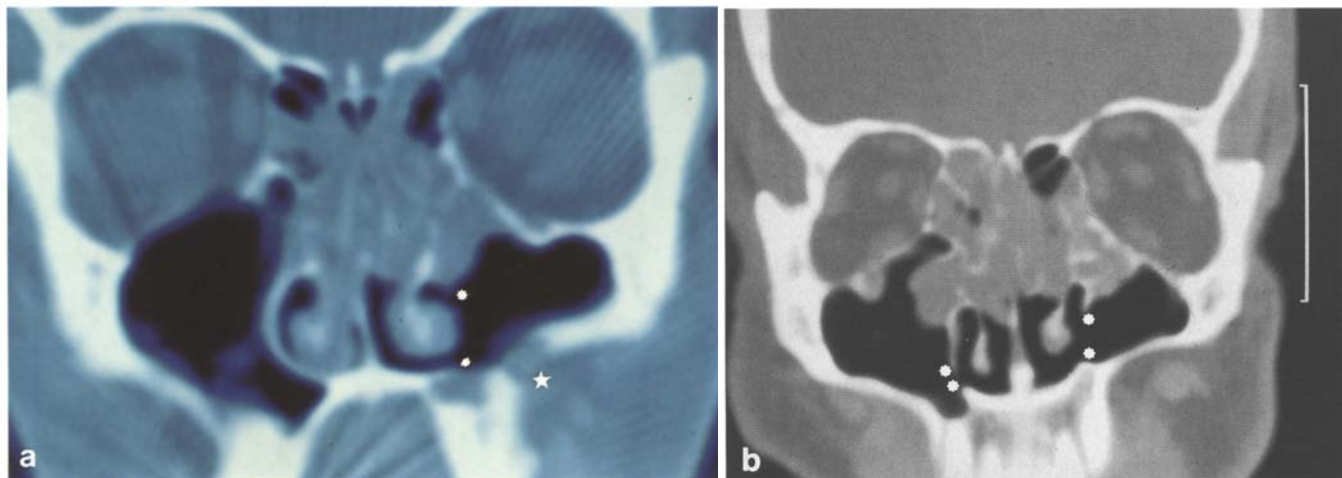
CT scans of patients after Caldwell-Luc (a) and fenestration operations (b) The remaining ethmoid disease is clearly demonstrated, explaining the patient's persisting clinical problems despite patent windows into the inferior meatus (*asterisks*). The *large asterisks* indicate bony defect in facial wall of maxillary sinus after Caldwell – Luc surgery (b by courtesy of S.J. Zinreich, MD, Baltimore)
